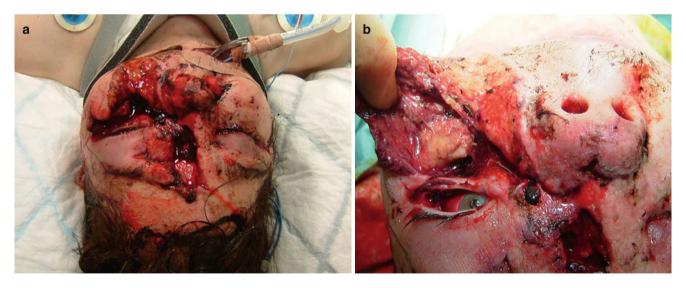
This patient had major soft tissue injuries and extensive fractures following a motor vehicle collision into a tree. The left cheek is sagging (a) and the lower eyelid has no support (b). The airway was secured, there was no active bleeding, and the brain CT was normal. Protection of the globe was the next priority from our perspective
